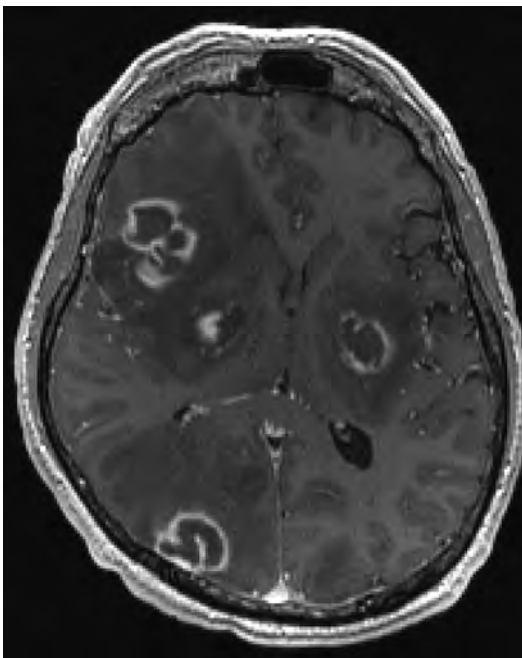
Cerebral toxoplasmosis: T1-weighted MRI showing multiple gadolinium-enhancing lesions with perifocal edema.
